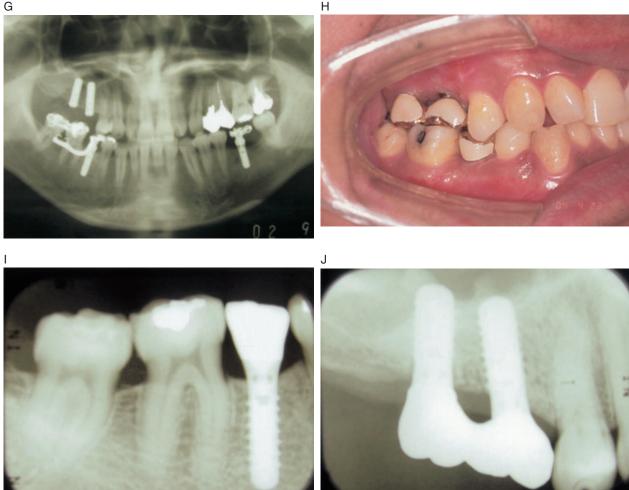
(continued) G, Panoramic X-ray taken after placing all implants. H, The final implant crowns and bridges were attached. I, X-ray of the anchor implants and intruded teeth 46 and 47 3 years after implant therapy. J, X-ray of the implants at teeth 16 and 17.
